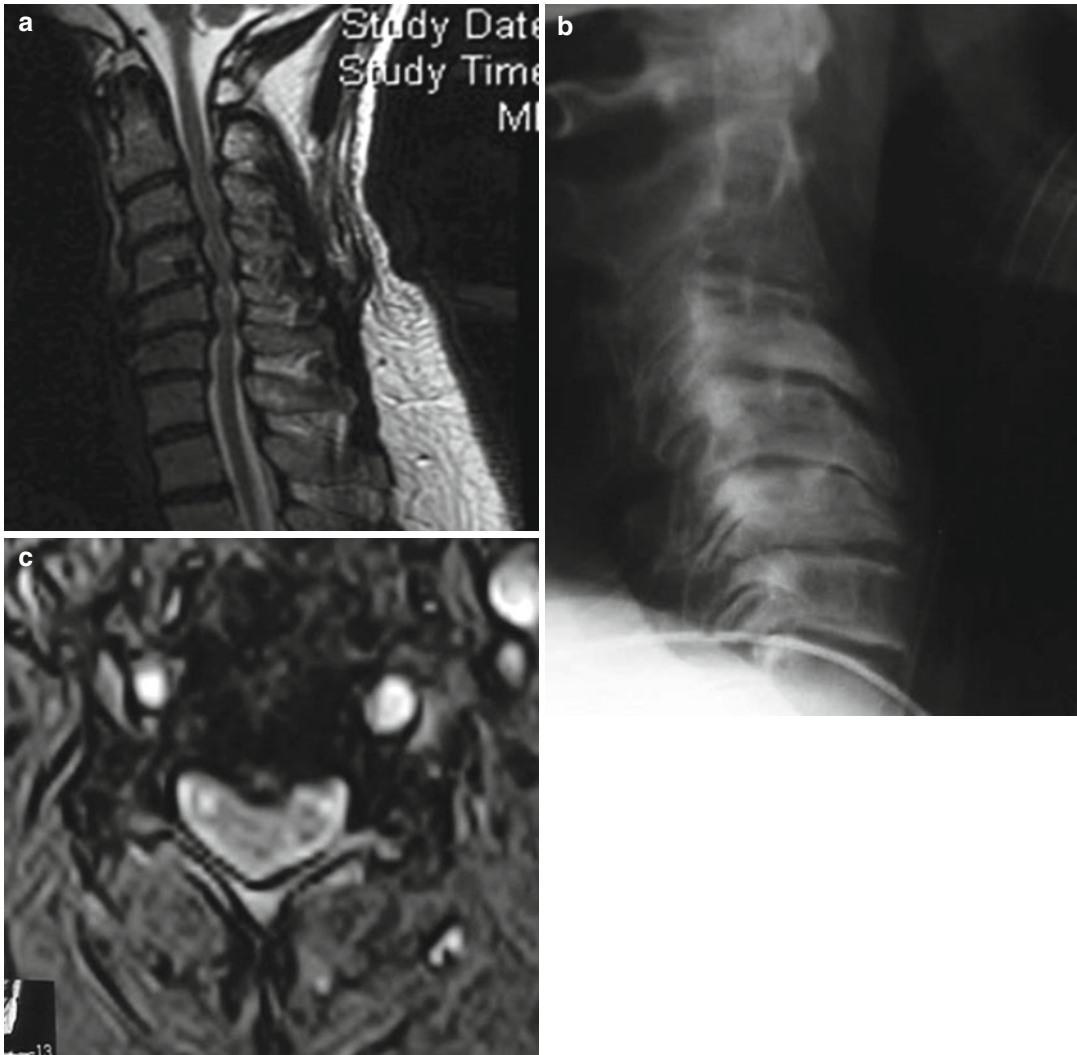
(a–c) MRI shows severe multilevel cervical stenosis. This patient fell from a chair and suffered a central cord syndrome
